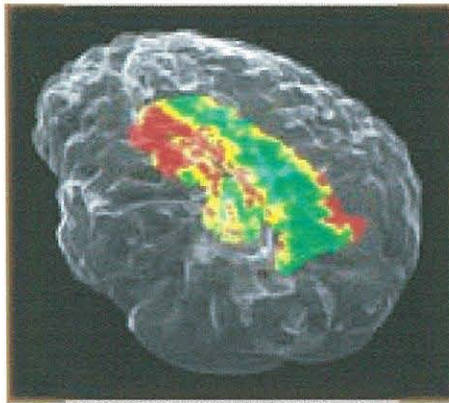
MRI image of gray outer surface of the brain and PET image of the inner cingulate gyrus (colored structure) that is part of the brain's emotional system. Photograph by Monte S. Buchsbaum, M.D. (PBS, 2001).
